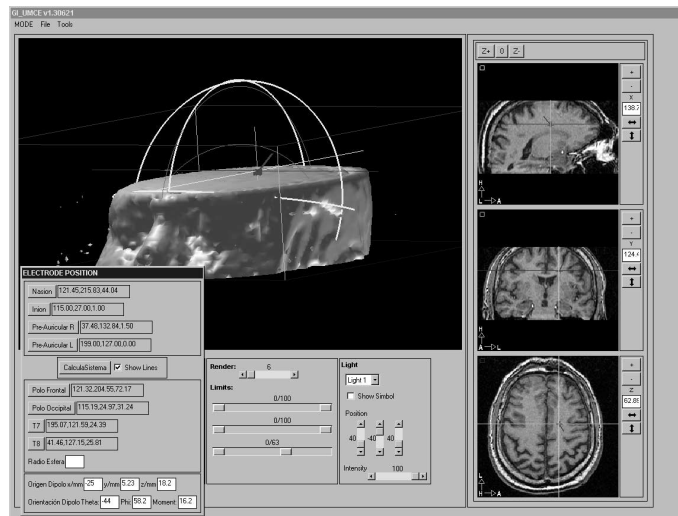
Dipole projection onto the patient's MRI and the sphere used in the electrical head model.
